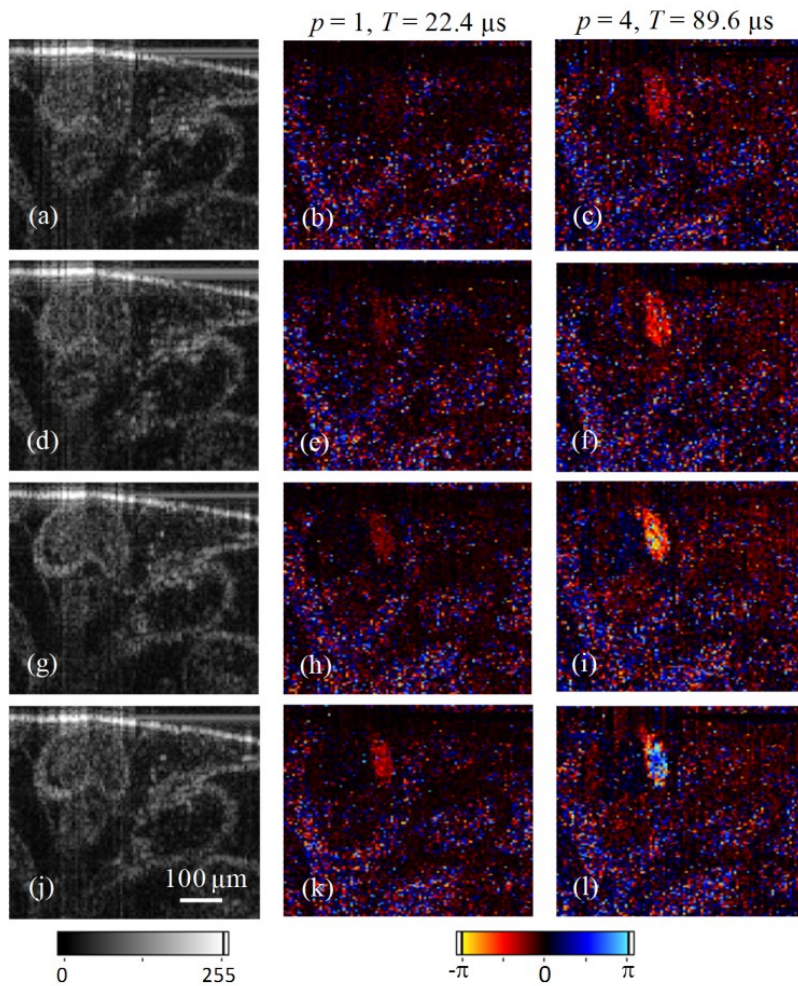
Doppler images of an African frog tadpole that were simultaneously acquired at the same location at different times where (a, d, g, and j) are intensity images, (b, e, h, and k) and (c, f, i, and l) are Doppler images corresponding to  $p=1$  and  $p=4$ , respectively.
